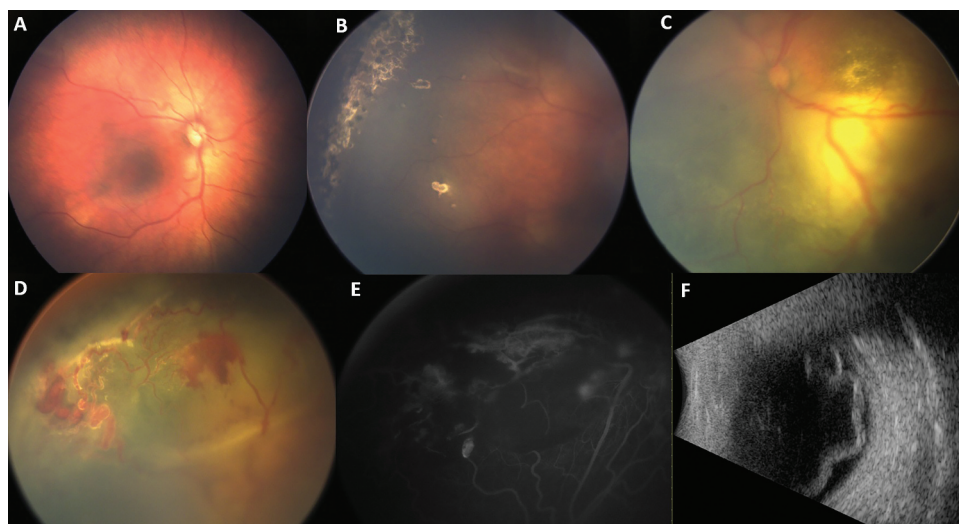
An infant born at 29 weeks of gestation initially diagnosed as aggressive ROP because of the dilated vessels which were misdiagnosed as plus disease, and subsequently treated with bilateral laser photocoagulation multiple times in elsewhere and was referred to us since it was still progressing. Fundus examination of the right eye revealed no vascular pathology (A) but only some peripheral laser scars (B). On the other hand, fundus examination of the left eye revealed shallow total retinal detachment with widespread hard exudates more concentrated in the inferotemporal arcuate (C) and telangiectatic and dilated twisted vessels in the highly elevated superonasal retina (D). Fundus fluorescein angiography highlights telangiectatic vessels and avascular retinal areas (E). Ultrasonography reveals total serous retinal detachment (F). Unilateral disease with extensive exudation and telangiectatic vessels were suggestive of Coats' disease in a premature baby. Laser photocoagulation of the peripheral avascular retina without ablating the telangiectatic vessels has most probably led to the development of exudative RD from continuous leakage from the telangiectasis.
